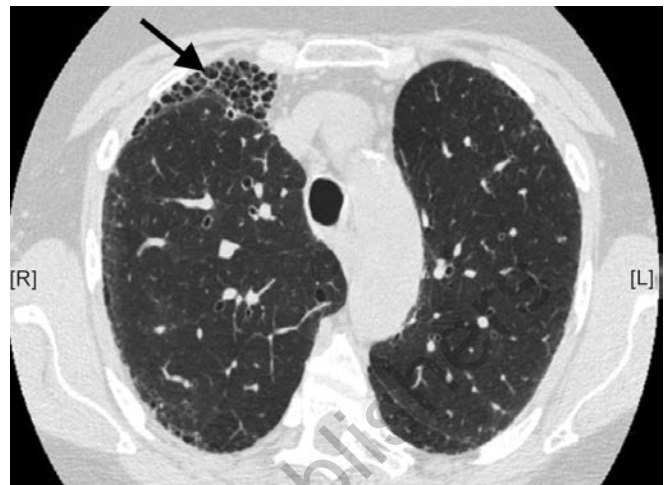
HRCT through the upper lung zones demonstrating numerous cysts (arrow) involving the subpleural regions resulting in honeycombing. Note dilated bronchi adjacent to branches of the pulmonary artery
